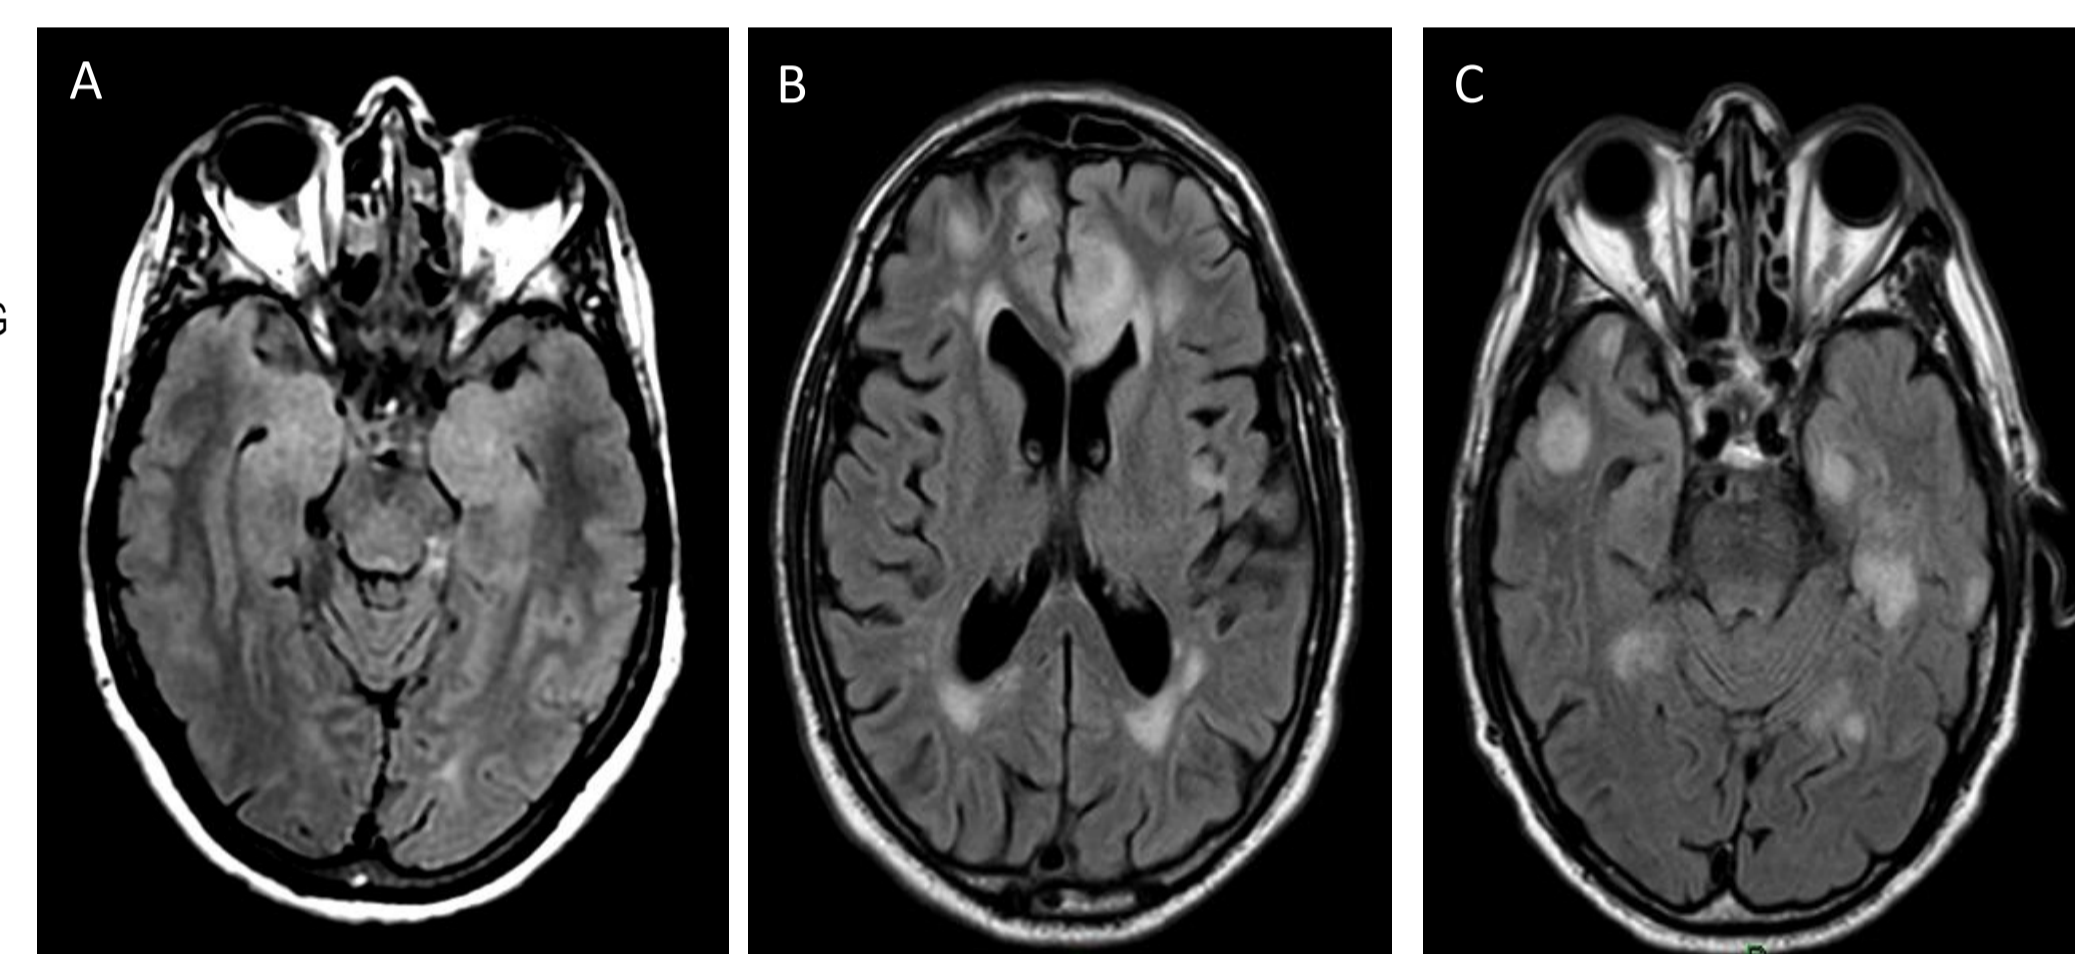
Brain MRI of patients with thymoma and autoimmune encephalitis. (A) Axial Fluid attenuation inversion recovery (FLAIR) brain MRI of a patient with limbic encephalitis and Lgi1-IgG showing hyperintense lesions in mesial temporal lobes. (B, C) Axial FLAIR brain MRI of a patient with autoimmune encephalitis and GABAAR-IgG showing multiple cortical-subcortical hyperintense lesions.
